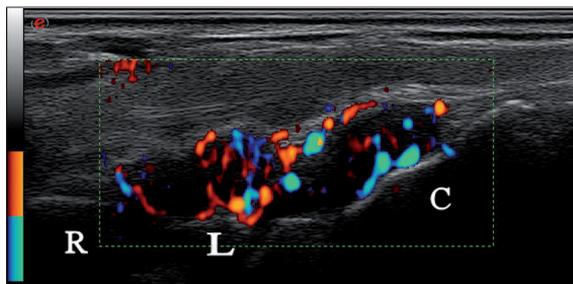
Synovial membrane inflammation in radio-carpal and intercarpal joints – grade 3. Dorsal sagittal US Power Doppler image. R – distal part of the radius, L – lunate bone, C – capitate bone.
